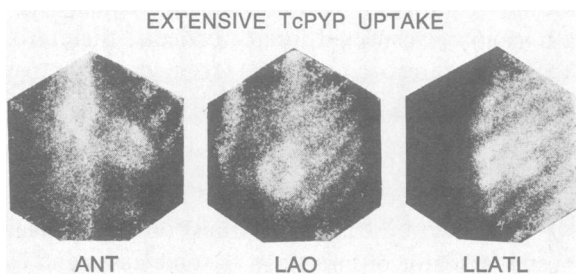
Extensive TcPYP uptake. The scintigram above shows extensive intramyocardial radionuclide accumulation in a patient with massive acute subendocardial infarction. The presence of the photopenic left ventricular cavity confirms the myocardial localization and separates the study from those with diffuse uptake. In this patient total CPK was more than 1,000 units with 65 percent CPK-MB. However, the patient presented with only mild congestive heart failure which responded quickly to therapy.
